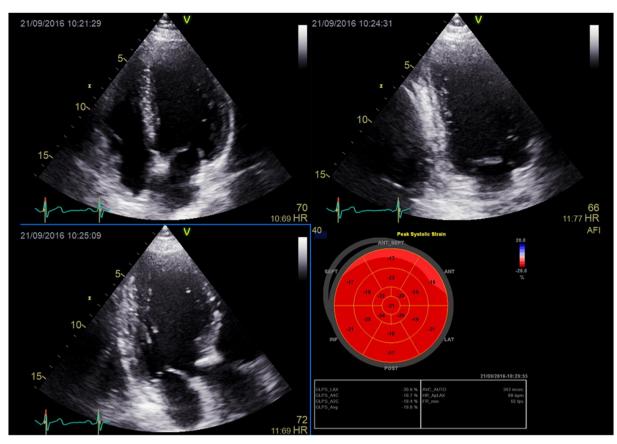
Measurement of global longitudinal strain from 17 segments from the apical views using the speckle tracking echocardiography method.
